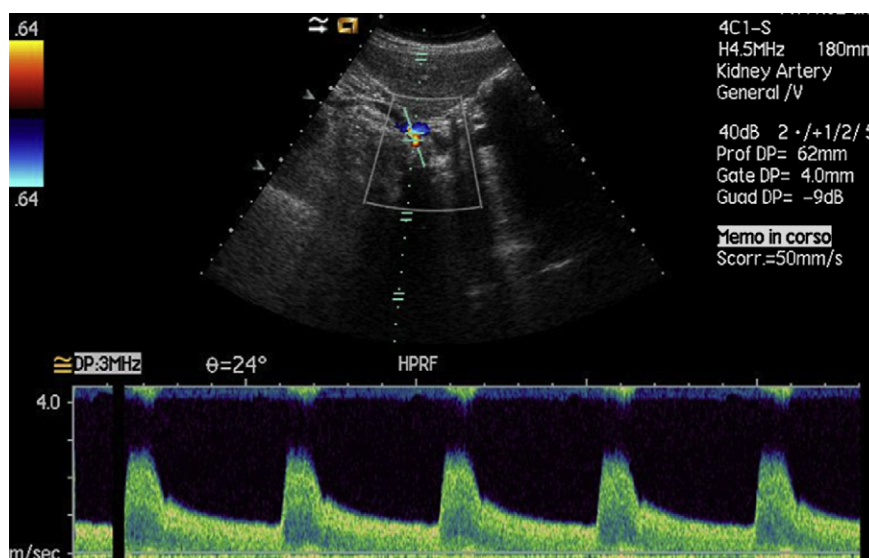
Spectral Doppler waveform of the stenotic area in the right RA. Increased peak systolic velocities are seen (PSV 286 cm/s); Mosaic flow is seen within the stenotic area.
